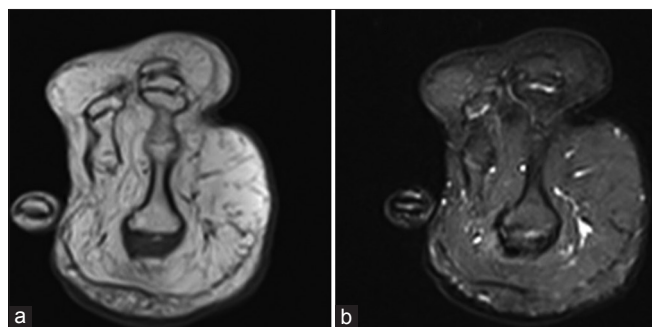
Axial magnetic resonance images demonstrating enlargement and marked proliferation of adipose tissue characterized by high signal on T1-weighted image (a) and signal suppression on fat-saturated T2-weighted image (b)
